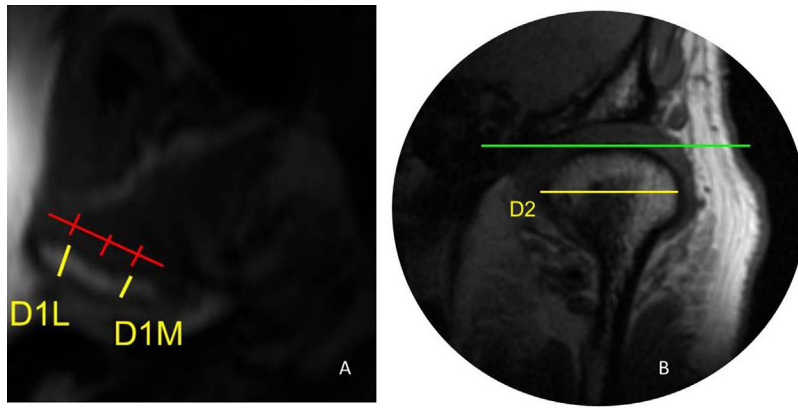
(A) MRI axial image of the right mandibular condyle, identifying the medial and lateral regions where D1L and D1M were measured. (B) MRI coronal image of the TMJ, showing the extent of D2 in the left mandibular condyle.
